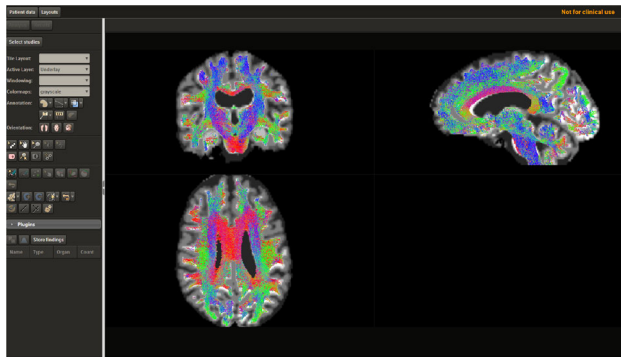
Overlay (intended display): White-matter tractography streamlines generated with multi-shell multi-tissue CSD (MRtrix3 tools used). Underlay: 5-tissue-type segmentations of coregistered T1-weighted data.
